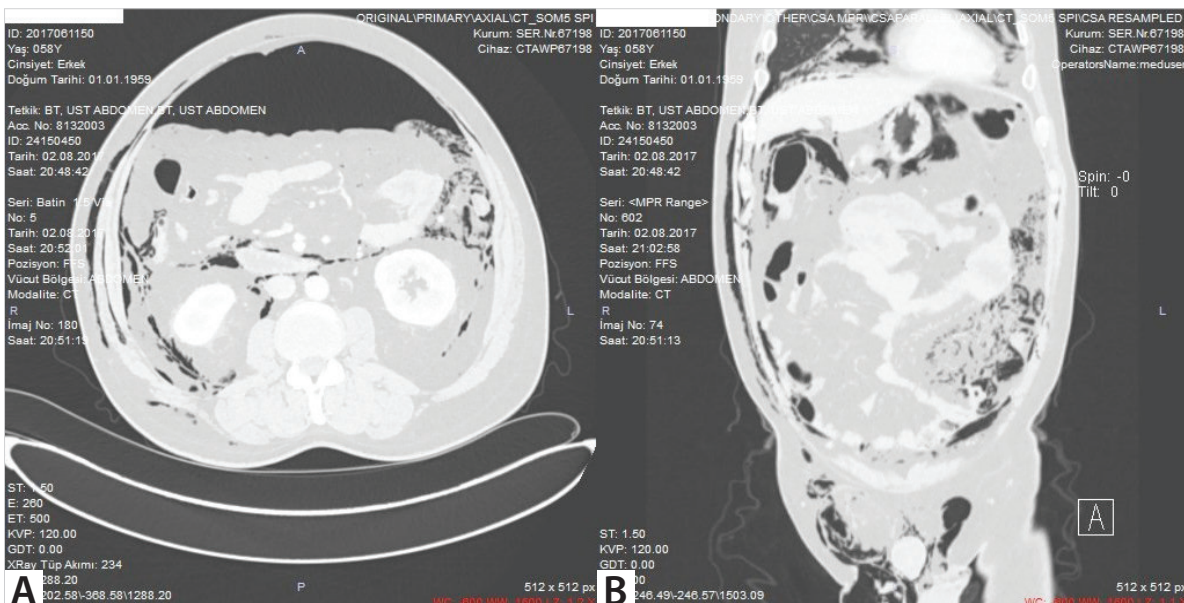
A. CT axial image after ESD, B. CT coronal image after ESD.
